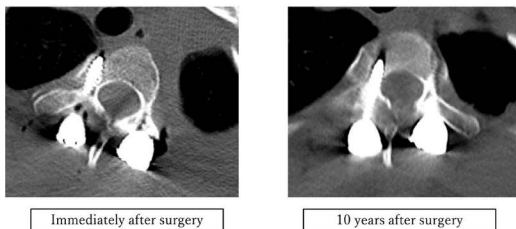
CT showed the right T2 pedicle screw perforated antero-laterally just after surgery was accommodated in the cancellous channel of the pedicle at 10 years follow up.
